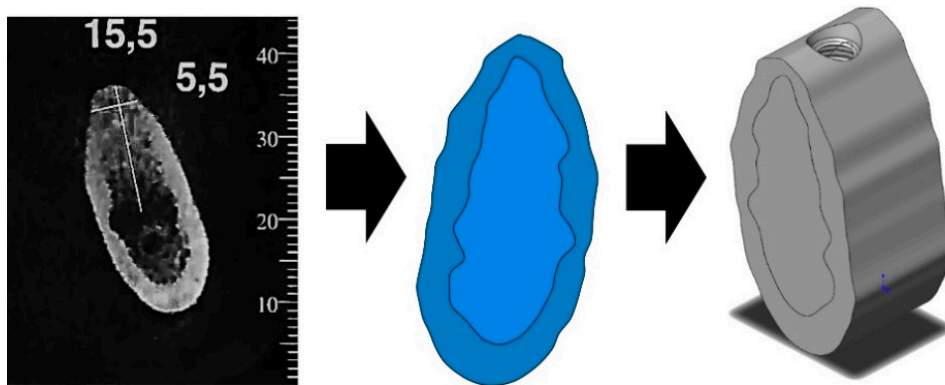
CBCT de una sección mandibular transferida a la geometría 3D.
